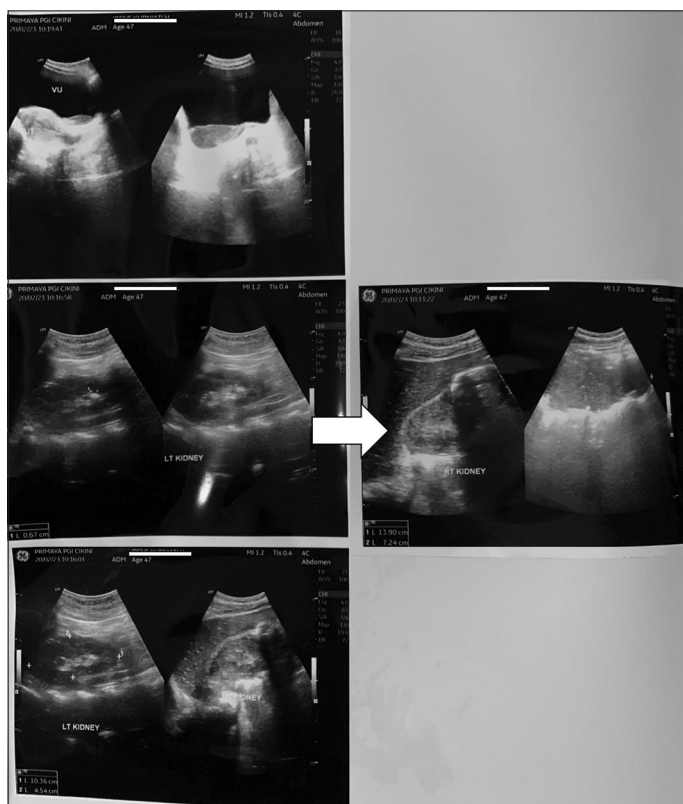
Ultrasonography of kidney. The white arrow indicated that the right kidney had a collection of fluid with internal echoes that appeared to contain an air component
